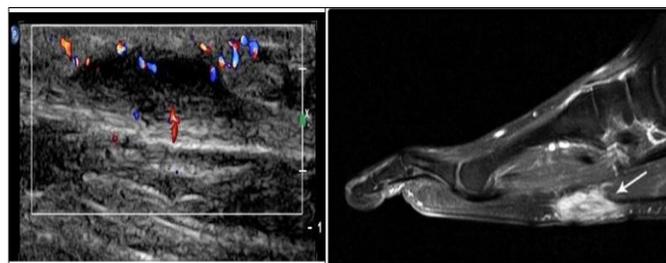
Ultrasound image showing a hypoechoic, fusiform lesion arising from the plantar fascia in the medial aspect of the arch of the right foot in keeping with a typical plantar fibroma. Minor vascularity is also detected.
